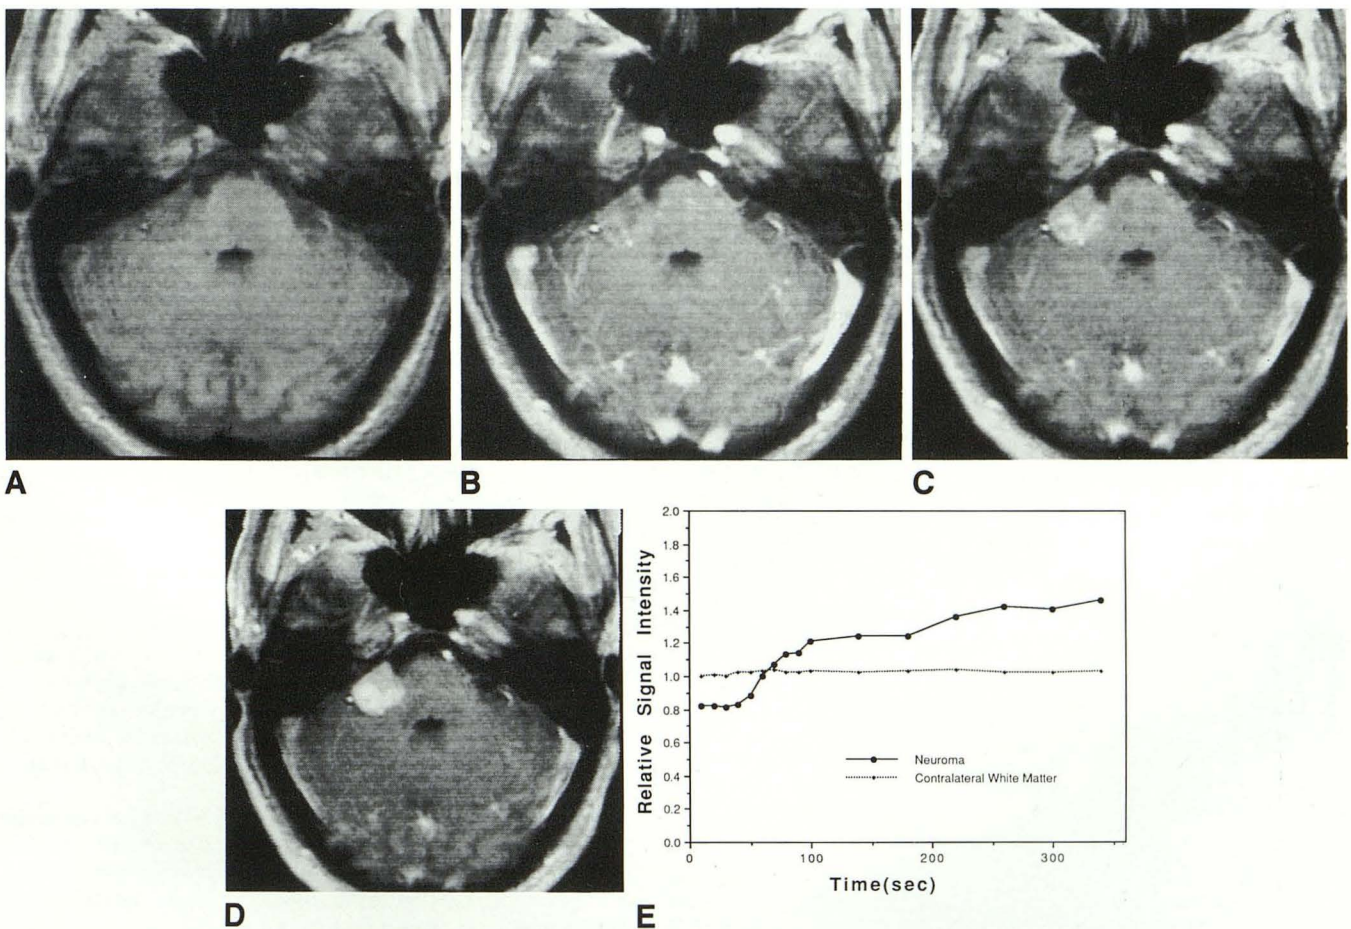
Dynamic MR images (A-D) and time-intensity curve (E) of right acoustic neuroma. The short TE FLASH sequence was employed: TR/TE/flip angle/NSA = 45/4/45/1, 192 × 256 matrix and section thickness = 8 mm. Before (A) and 20 (B), 80 (C), 320 (D) sec after administration of Gd-DTPA. In the early image (B), the first passage of Gd-DTPA is seen in the arteries and veins. At this time, the tumor demonstrated only weak enhancement peripherally and entire enhancement with maximum signal intensity in the late image (D). The time-intensity curve of the tumor (E) corresponded to type 1, ie, gradual enhancement with no peak pattern. Normal contralateral white matter showed almost no discernible enhancement.
